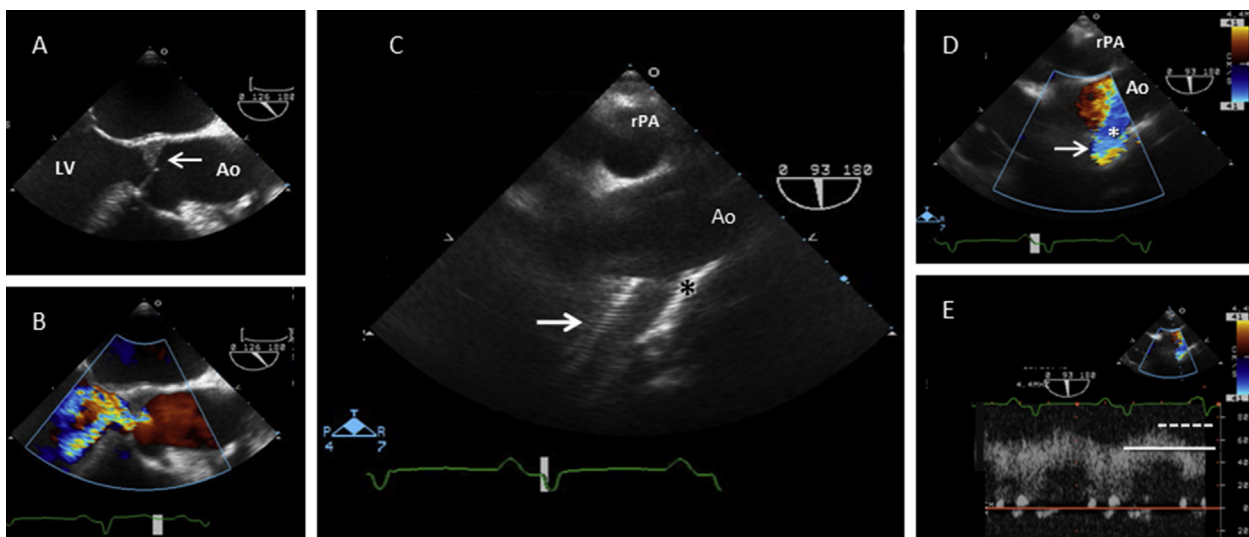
TEE characteristics of severe AR due to aortic cusp fusion associated with longstanding LVAD support. (A) Mural thrombus within the AV noncoronary cusp (*arrow*). See also [Video 17](#). (B) Severe AR, as detected by color-flow Doppler. See also [Video 18](#). (C) Using the right pulmonary artery (rPA) as an acoustic window, an upper esophageal long-axis view of the ascending aorta (Ao) shows the LVAD outflow graft (*arrow*) and its ascending aortic anastomosis site (*). (D) Color-flow Doppler evaluation of the outflow-graft-aorta anastomosis. See also [Video 19](#). (E) Pulsed Doppler assessment of the outflow anastomosis reveals a laminar signal with high flow characterized by nearly equal systolic (*dotted line*) and diastolic (*solid line*) velocities (*arrow*), consistent with severe AR.
